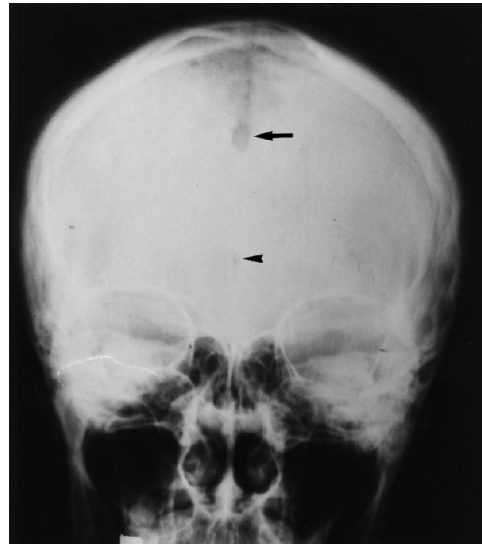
Plain skull radiograph shows an oval bony defect at the lambda (arrow) and another small bony defect (arrowhead) in the midoccipital region.
